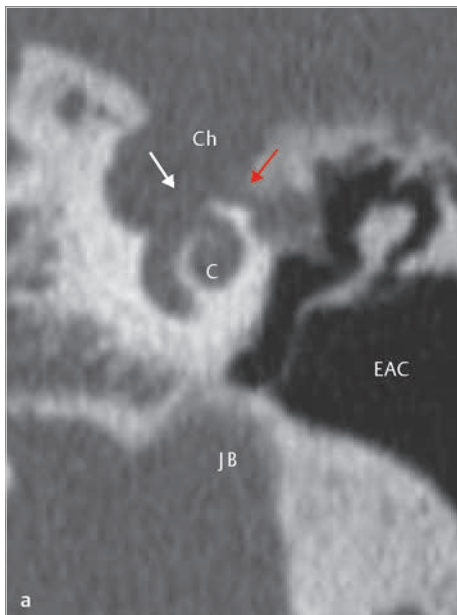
The coronal CT images at the level of the apical turn of the cochlea (a) and the area just anterior to the footplate (b) demonstrate presence of cholesteatoma infiltrating the cochlea (white arrow) and the internal auditory canal (yellow arrow). The fallopian canal is also infiltrated in the labyrinthine segment (red arrow) and the tympanic segment (black arrow). The rough surface of the bone in the medial wall of attic is suggestive of bone erosion. A very large, anteriorly located jugular bulb is seen in the floor of the tympanic cavity. C, cochlea; Ch, cholesteatoma; EAC, external auditory canal; IAC, internal auditory canal; JB, jugular bulb.
